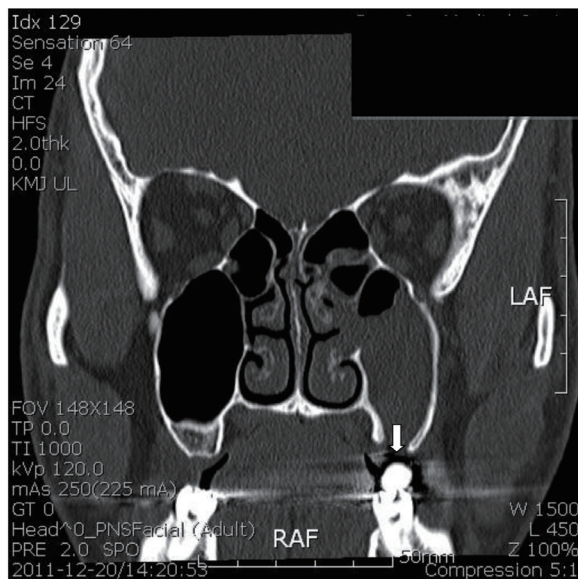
CT scan showed a bony defect of left maxillary sinus floor.
